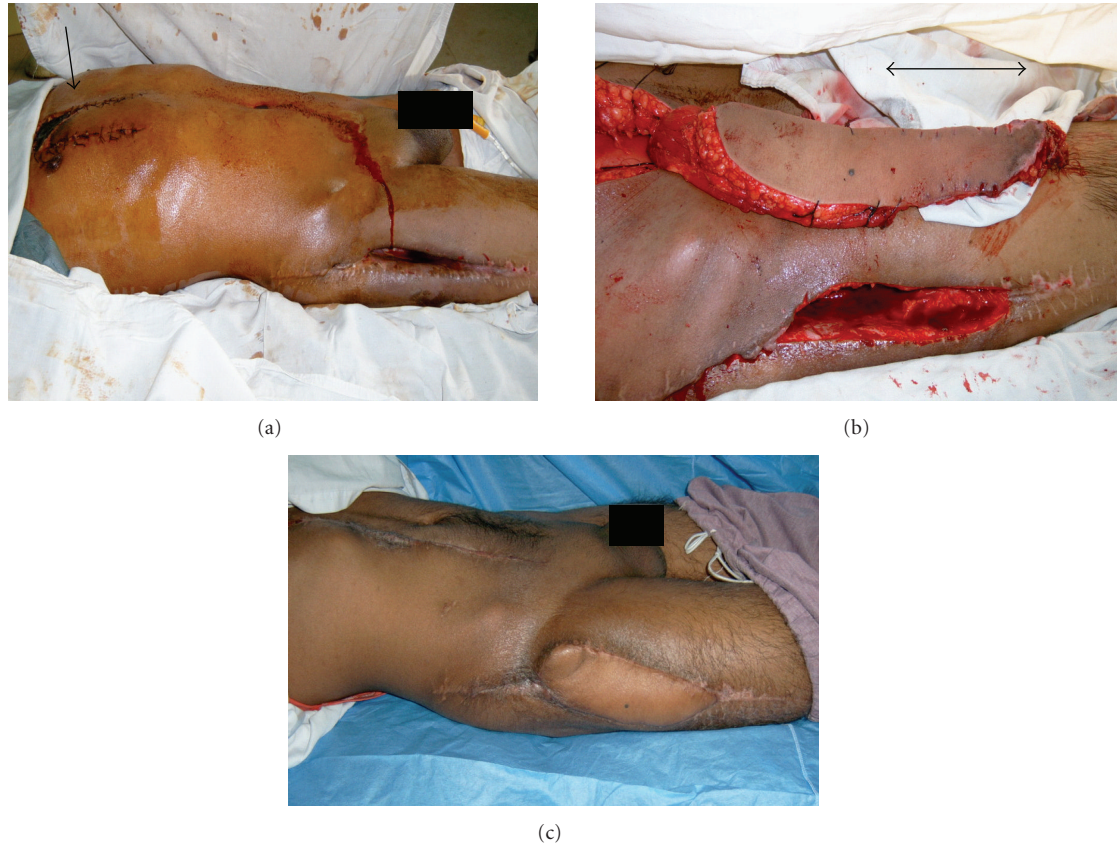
(a) A two-week picture after delay procedure (surgical and vascular delay) for extended inferiorly based VRAM flap. The arrow points to line of demarcation between nonperfused and augmented perfused skin in the parasternal fasciocutaneous extension of the VRAM flap. This extension provided additional predictable length of 7 cm for coverage of exposed plate femur after osteosarcoma resection of the proximal femur. (b) Intraoperative picture after harvesting of VRAM flap and debridement of necrotic thigh flap. The VRAM extension marked by the suture markings of the delay procedure provides the extra length avoiding tension and providing durable coverage. (c) Postoperative picture 3 months during chemotherapy course showing complete survival of the flap providing stable coverage and complete healing of the donor site.
